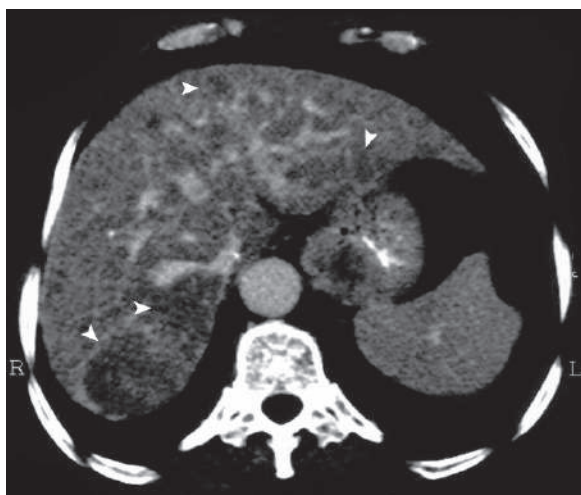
Axial abdominal-enhanced CT shows multiple hypodense lesions in a patient with liver TB representing tuberculomas (arrowheads)
